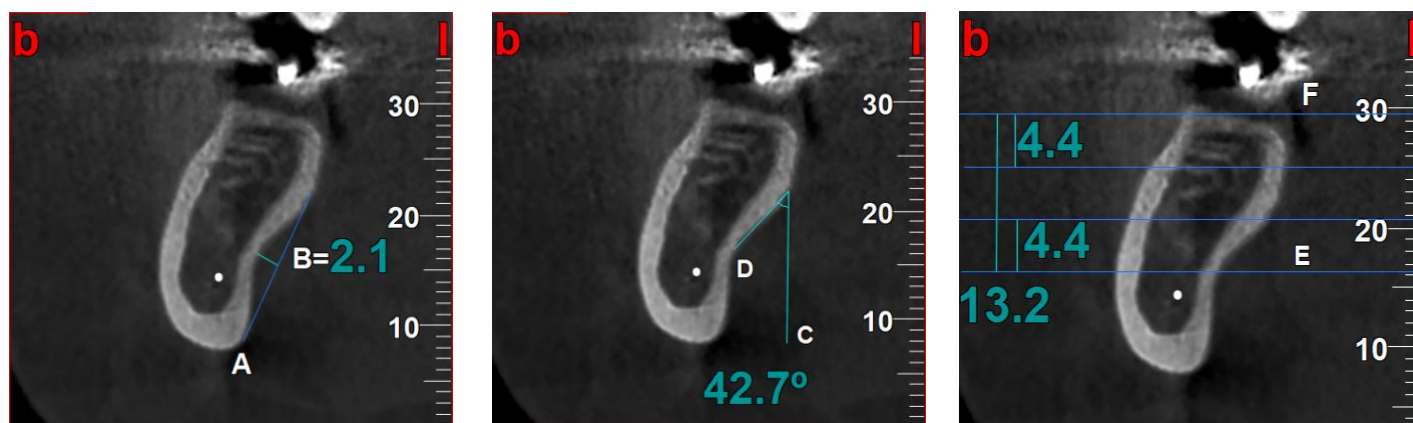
Cross-sectional CBCT view measuring the depth of the fossa (left), Cross-sectional CBCT view measuring the angle of the fossa (middle), Cross-sectional CBCT view measuring the starting point of the undercut (right).
